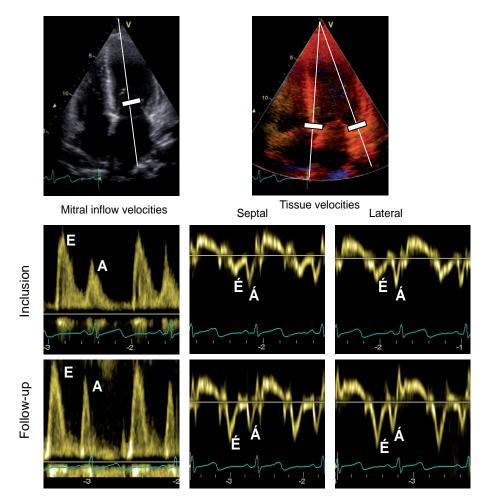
Example of pulsed Doppler recordings of mitral inflow and pulsed Doppler tissue imaging at inclusion and at follow-up in a patient with preeclampsia.
